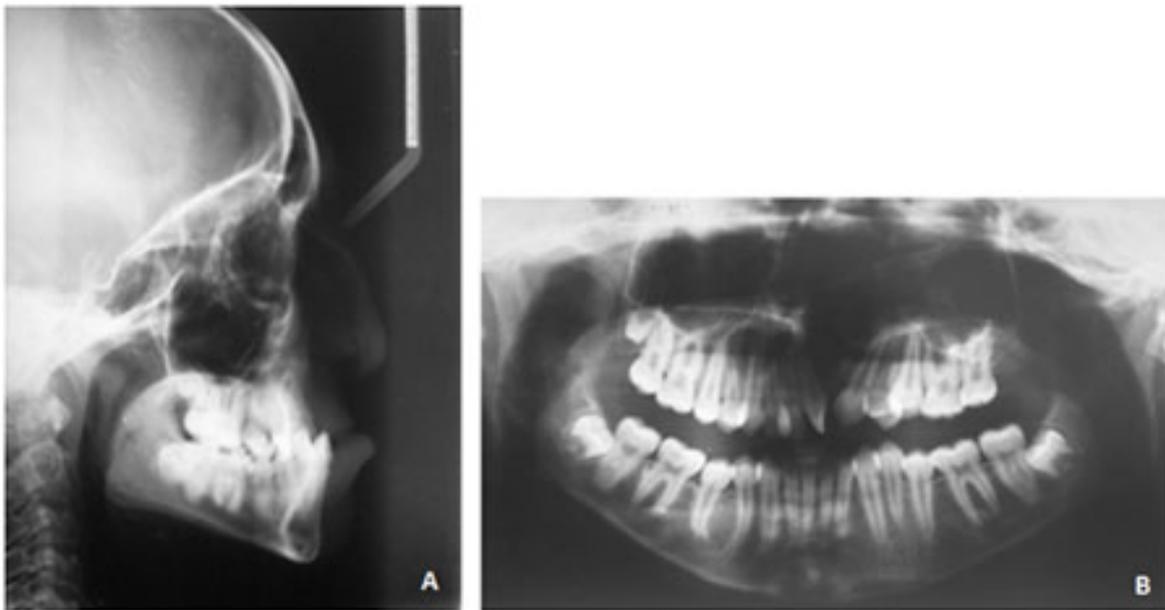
Pre-treatment radiographs: lateral cephalogram (A) and panoramic radiograph (B)
